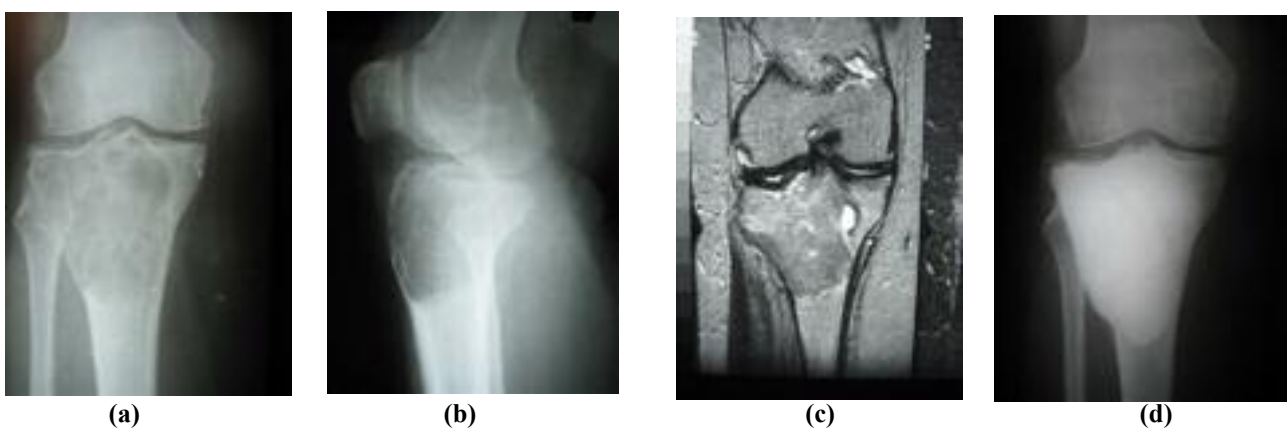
A 51 year old female with right proximal tibia giant cell tumor; AP x-ray (a), Lateral x-ray (b), MRI (c), AP x-ray 2 years after curettage with high speed burr and cementing without recurrence (d).
